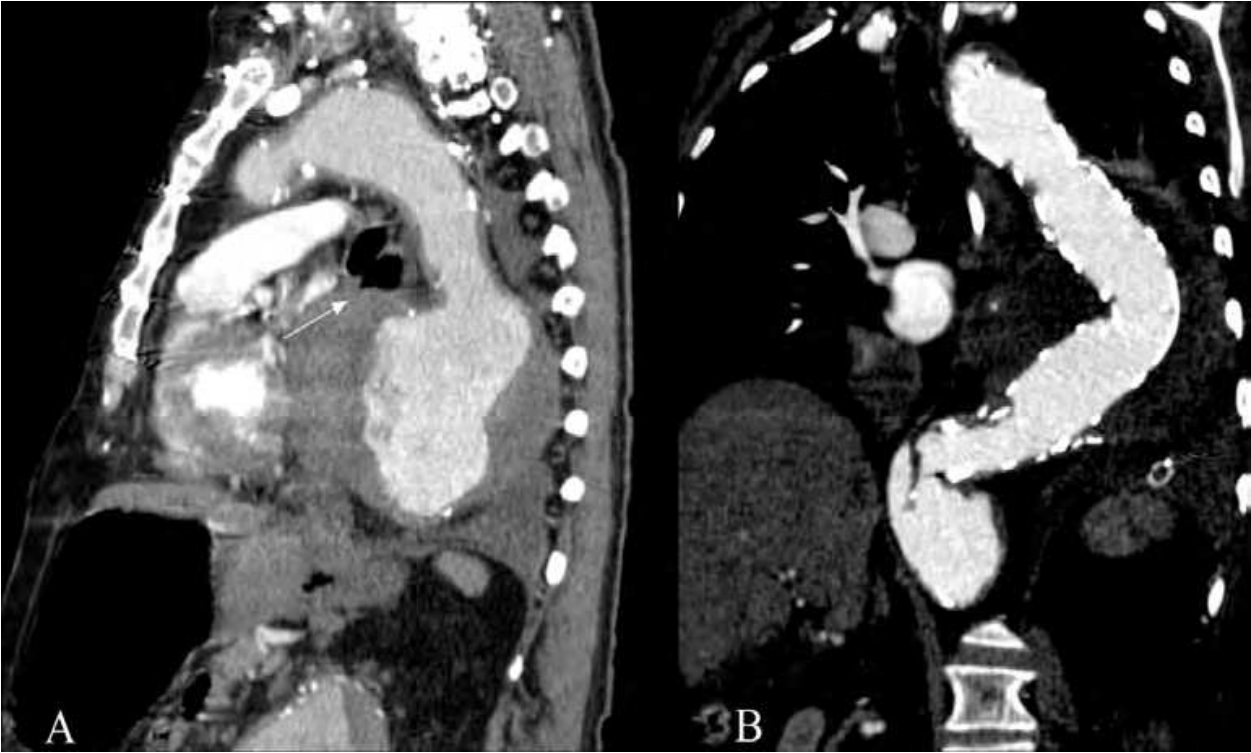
Case 23. A, Chest computed tomography scan showing complete contact between a thoracic aortic aneurysm (10 cm in diameter) and the esophagus (arrow), causing an aortoesophageal fistula. B, Computed tomography scan showing accurate placement of endoprosthesis (postoperative day 2), with successful exclusion of the aortoesophageal fistula and aneurysm.
